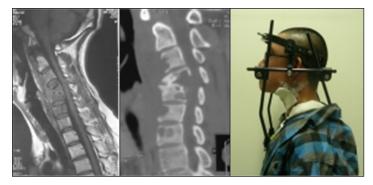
Three months after the operation, MRI showed that the posterior pharynx's abscess disappeared, CT showed that the C4-5 was fused.
